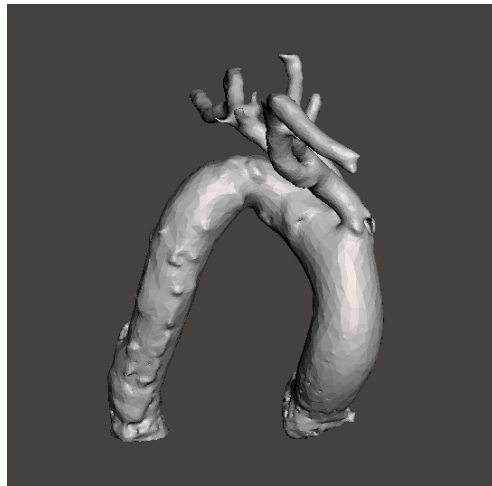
Original CT scan opened in MeshMixer with 54,190 triangles.
